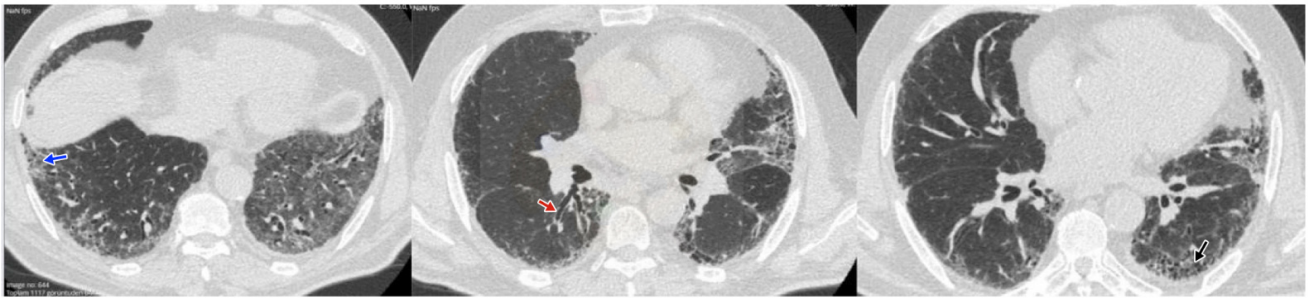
High-Resolution Computed Tomography image showing subpleural reticulations (blue arrow), traction bronchiectasis (red arrow), and honeycombing (black arrow) consistent with the usual interstitial pneumonia pattern.
